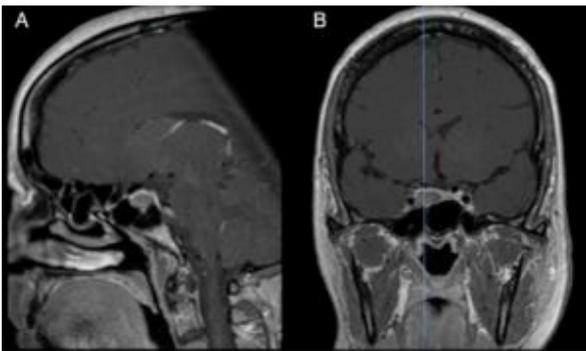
Sagittal (A) and coronal (B) T1-weighted cerebral MRI after gadolinium administration showing a sellar gangliocytoma coupled with a pituitary adenoma. The radiological features are similar to an isolated pituitary adenoma. The coronal view (B) shows an invasion of the right cavernous sinus.
